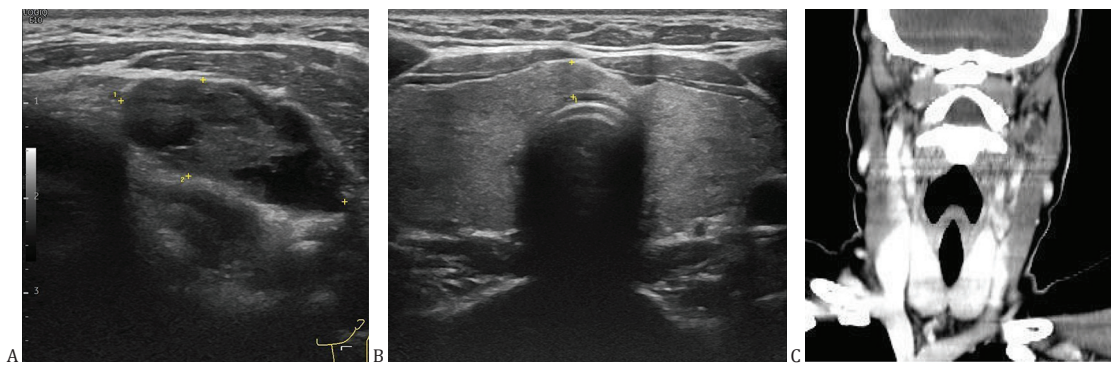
Radiologic finding. (A) Ultrasound of the neck revealed several enlarged and prominent nodes with partial necrosis or cystic change at left sided neck, (B) Ultrasound of the neck revealed no suspicious mass at thyroid gland, (C) Computerized tomography scan revealed multiple enlarged left cervical nodes at level IIb, III, IV with some with necrosis and the included thyroid gland appears normal.
